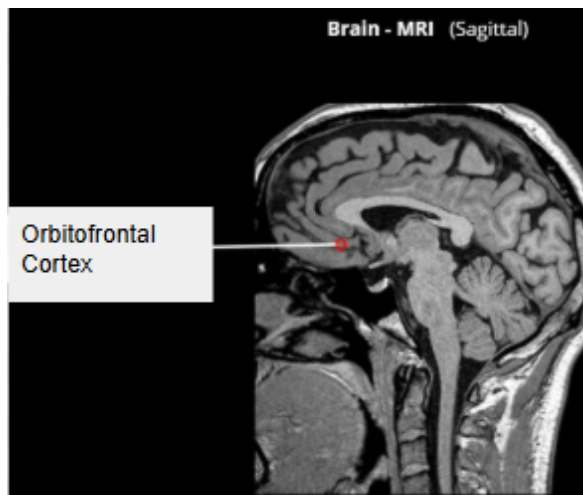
Regions of the brain associated with decreased grey matter volume in congenital anosmia. Courtesy of IMAIOS © “Antoine MICHEAU, MD , Denis HOA, MD Authors affiliations, Publication date: Aug 25, 2008, Anatomy of the brain (MRI) - cross-sectional atlas of human anatomy, <https://doi.org/10.37019/e-anatomy/163>
